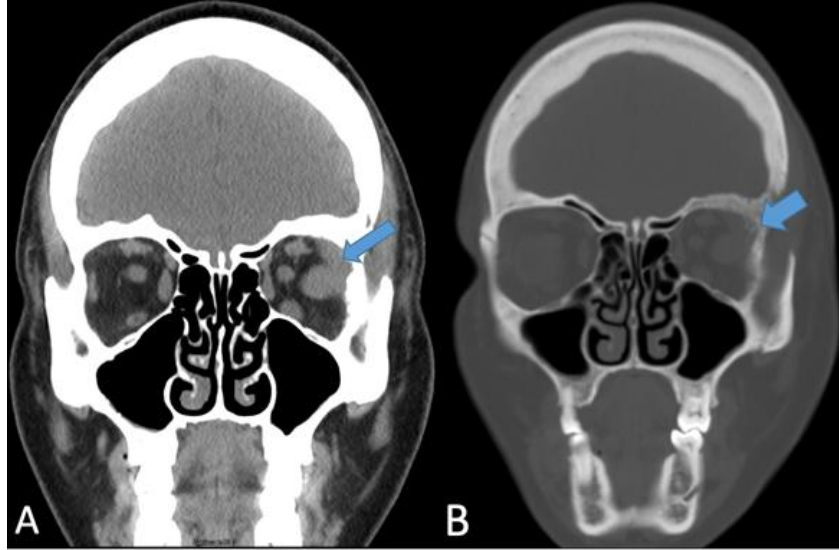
Coronal non-contrast CT. Soft tissue window (A) shows thickening of the extraconal adipose tissue adjacent to the left lateral rectus muscle (arrow). Bone window (B) demonstrates associated osteolytic and osteosclerotic remodeling of the frontal bone (arrow), characteristic of spheno-orbital meningioma with osseous involvement.
